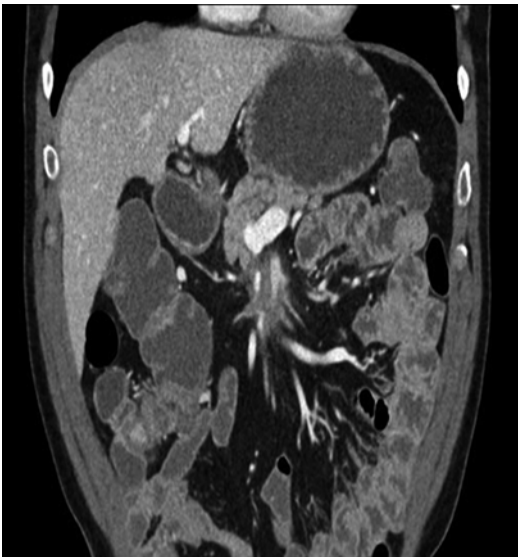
Radiographic example of truly unresectable SMA/SMV tumor infiltration into mesenteric root
